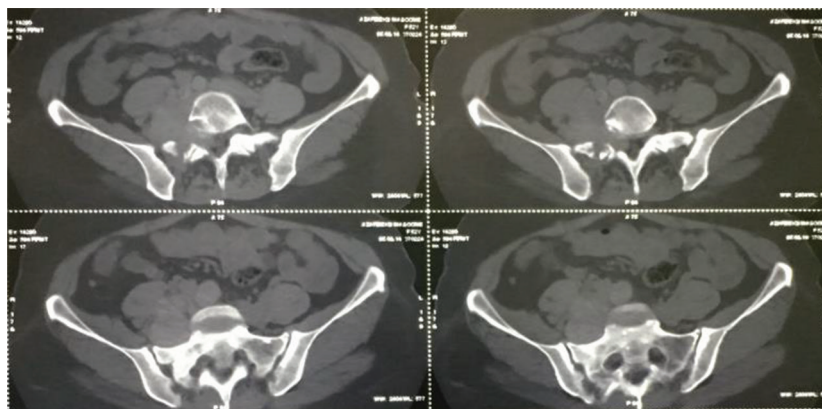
Axial CT scan view at L5 and S1 level. The tumor expanded the right S1 foramina and extended into the retroperitoneal space. Bone erosion was seen. CT, computed tomography.
